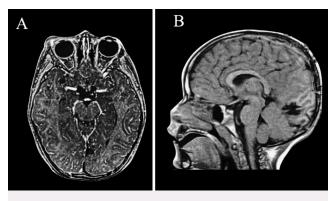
Postoperative MR images. A: Axial T1-weighted postgadolinium image. B: Sagittal T2-weighted FLAIR image revealing no residual tumor.
